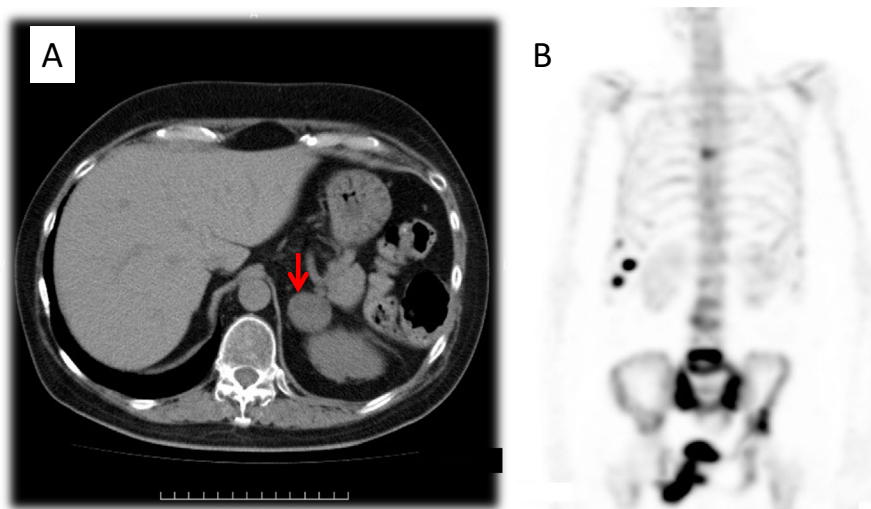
Computed tomography (CT) and whole-body ^{99m}Tc -methylene diphosphonate bone scintigraphy. (A) CT revealed a 30-mm left adrenal tumor (arrow). (B) A bone scan showed a significant abnormal isotope uptake in multiple ribs and vertebrae, the sacroiliac joints, and the right ileum.
